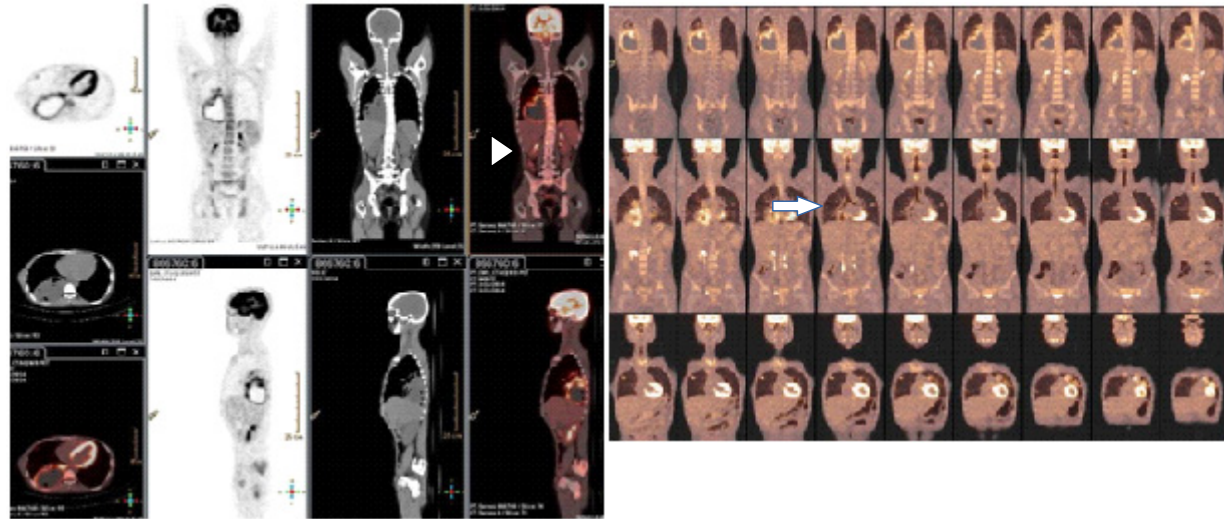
FDG-PET/CT showing a large loculated collection (with interspersed air pockets) with peripheral FDG uptake (arrowhead) and central photopenia in the right pleural space posteriorly and multiple FDG avid rounded nodules in both lungs (arrow)
